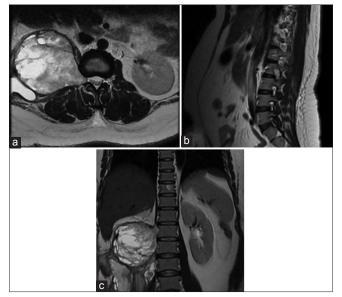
Magnetic resonance imaging examination of the (a) axial, (b) sagittal, and (c) coronal section of the T2-weighted sequence showed an extradural mass lesion that extended to the peritoneal cavity.
